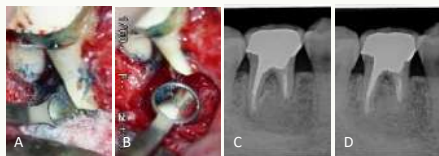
(A,B) Periradicular re-surgery of tooth #30. Complete loss of buccal cortical bone and access of lateral foramen on distal middle surface of mesial root. Located a lateral canal of mesial root during root resection procedure. (C) Post-operative radiograph. Root section to remove the lateral canal. Retrograde preparation and filled with MTA. Periradicular bony defect was filled with bone graft. (D) 20-month follow up radiograph. The lateral lesion healed uneventfully.
